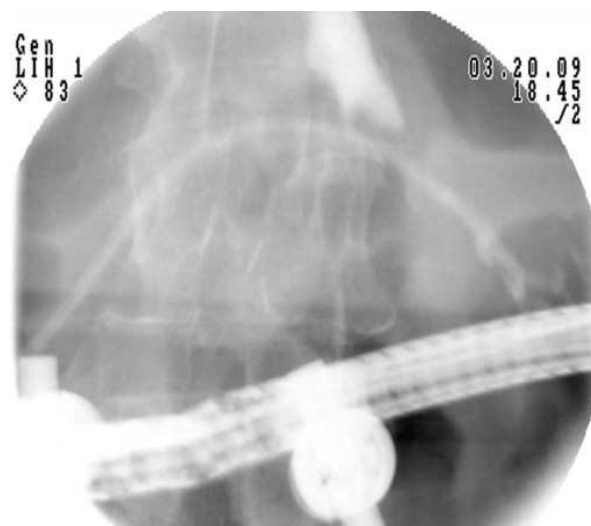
Radiographic image following placement of a 7Fr transpapillary stent across the pancreatic leak.
